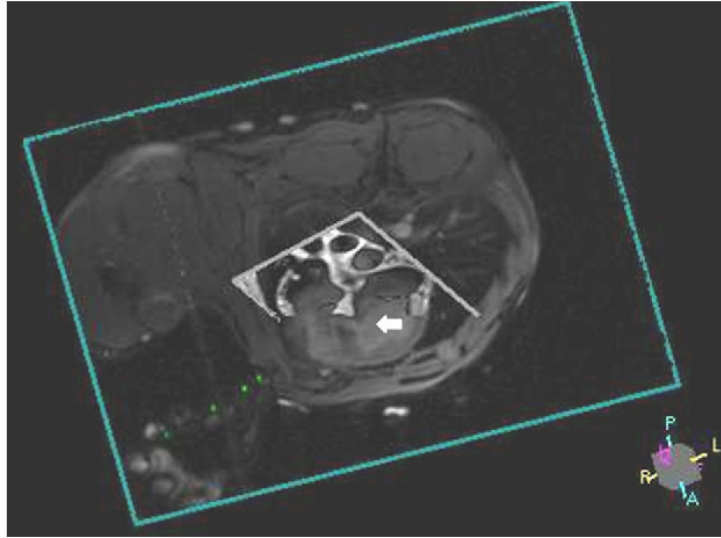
Real-time MRI Imaging Display During Closed-Chest Transthoracic Needle Access Targeting Muscular VSD
